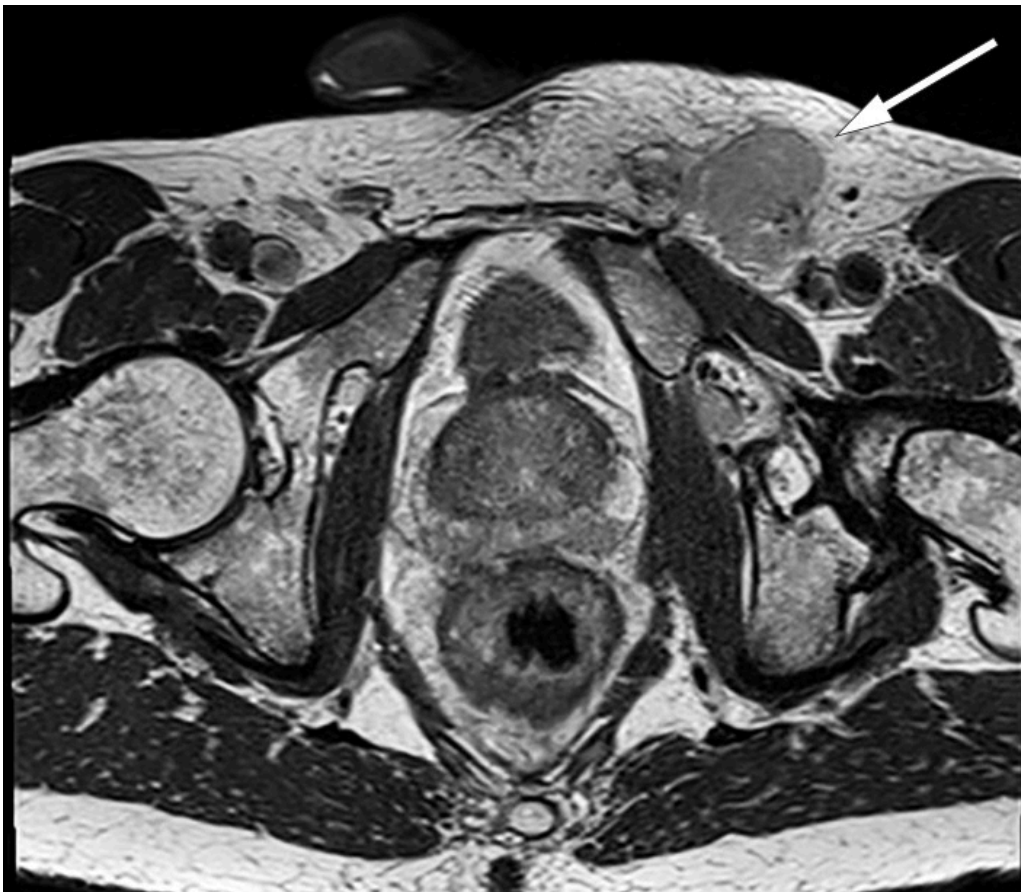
MRI, axial view of pelvis, with enlarged lymph node in left inguinal region (arrow).
